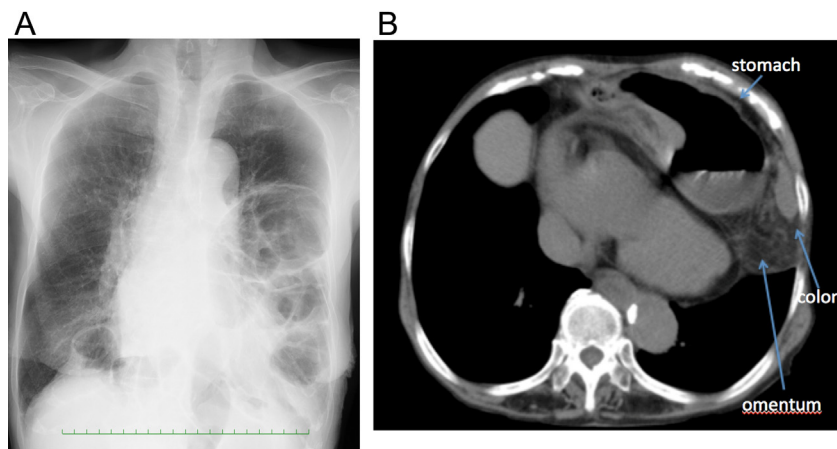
(A) Chest radiograph showing colonic gas above the left diaphragm in the left middle and lower lung zones. (B) Chest computed tomography scan showing the transverse colon, greater omentum, and stomach incarcerated in the left pleural cavity.
